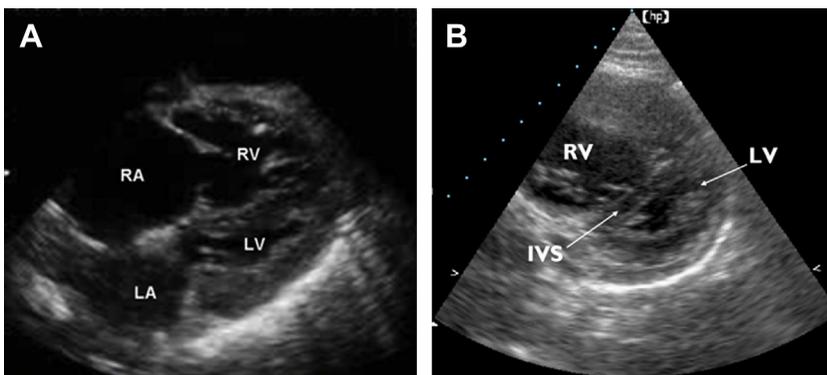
Transthoracic echocardiography images in a patient with massive PE, with (A) subcostal long axis view showing acute right heart dilatation, with the RV larger than the LV and (B) parasternal short axis view showing a small compressed LV, which is D-shaped with a flattened IVS, and a dilated RV. IVS, interventricular septum; LA, left atrium; RA, right atrium.
